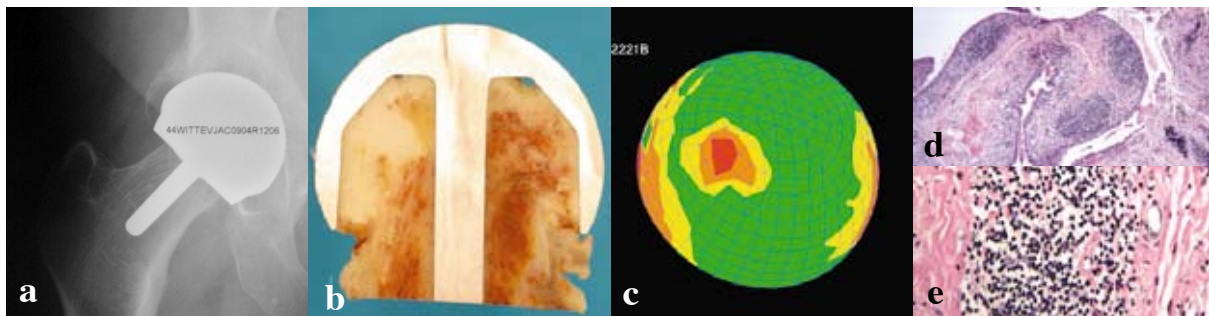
(a) X-ray of a right BHR in 63 year old female revised for suspected metal sensitivity, osteolysis in the pelvis and femoral neck narrowing (38 months follow-up), (b) mid-section of the retrieved femoral head showing neck narrowing in the absence of wear. (c) CMM measurement of femoral component with maximum femoral wear depth of only $4.7\mu\text{m}$. (d)(e) Villous synovium with extensive lymphocytic infiltration and relatively few macrophages. Taken together, the analyses indicate that this is a case of metal sensitivity. Contrast to the case in figure 10, revised for acetabular malposition and wear.
